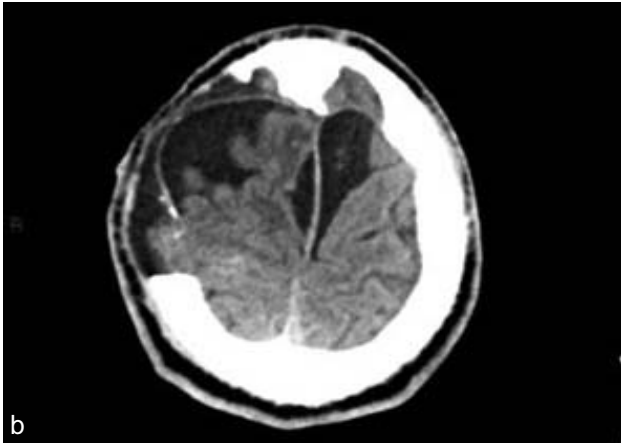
Computed Tomography, axial section. A: Initial post-operative scan with large hyperdensity in right fronto-parietal region consistent with subdural hematoma. B & C: Subdural hematoma with blood levels layering at dependant part of hematoma. Post surgical changes of isodense collection, air, edema and bleed are also seen.
